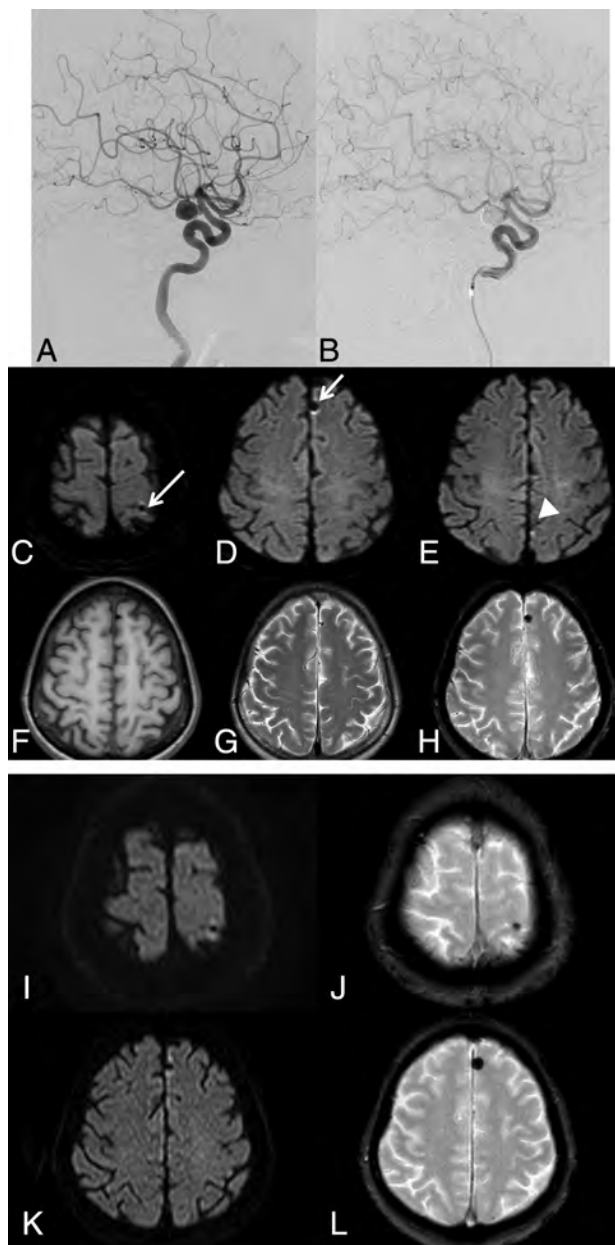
A left ICA aneurysm in case 1 (A) is embolized by using multiple coils (B). Postprocedural DWI shows abnormal low-intensity spots with a hyperintense halo (white arrow) in the left parietal (C) and frontal (D) lobes. These are different from a bright spot in the left parietal lobe (E), indicating thromboembolism. These abnormal spots are low intensity on T1WI (F) and T2WI (G) and show a blooming effect on T2*-weighted images (H). Follow-up MR imaging obtained 13 months after the procedure shows that all the abnormal signal spots remain without any signal changes (I–L).
